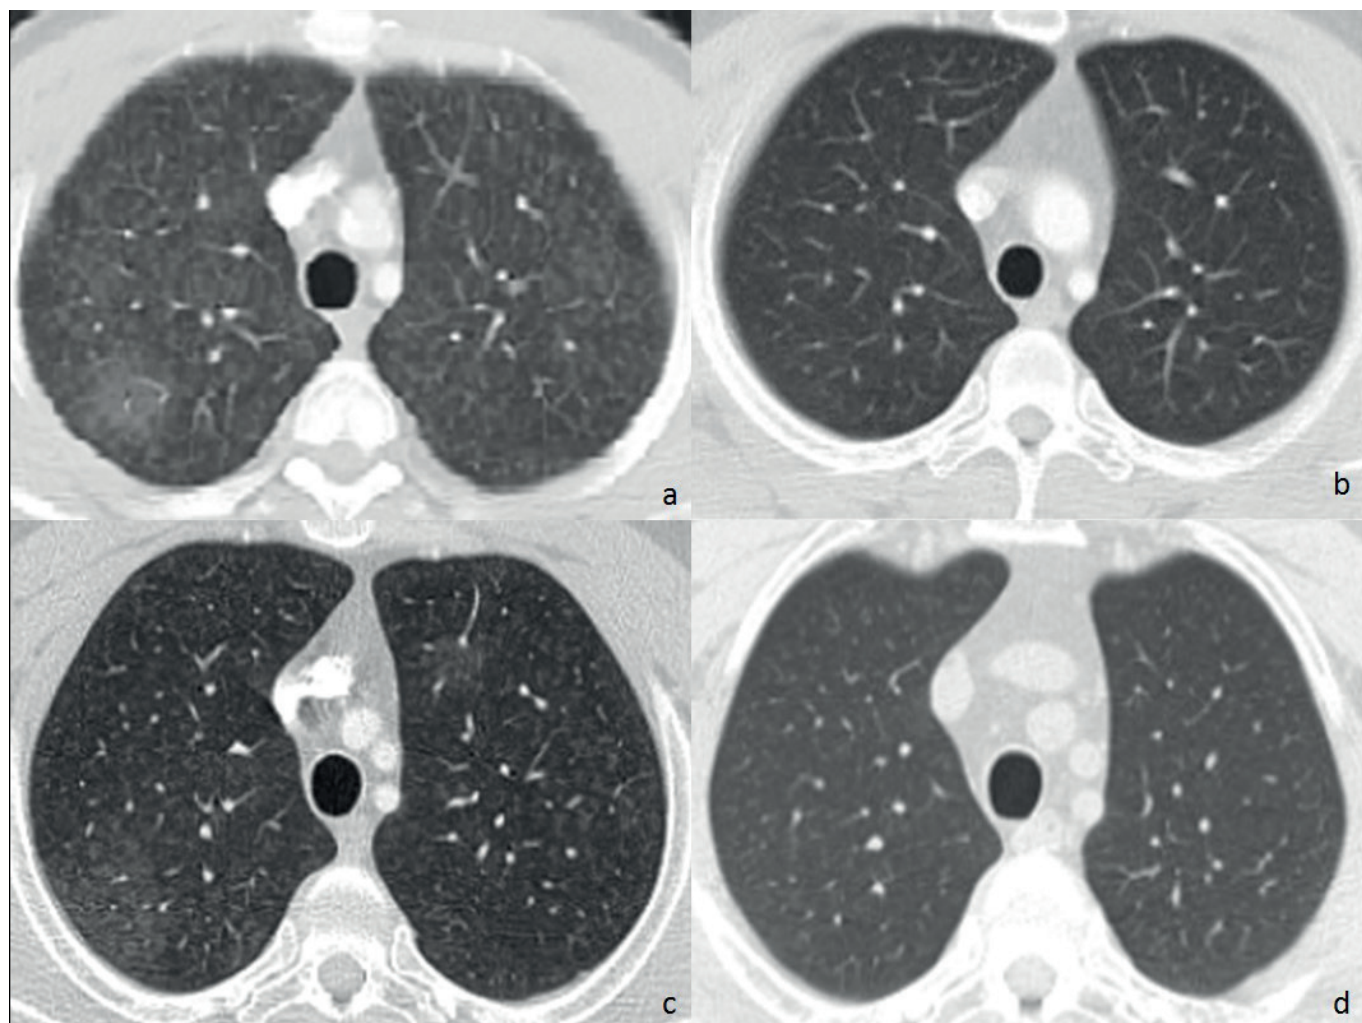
HRCT sections of the patient in different periods
